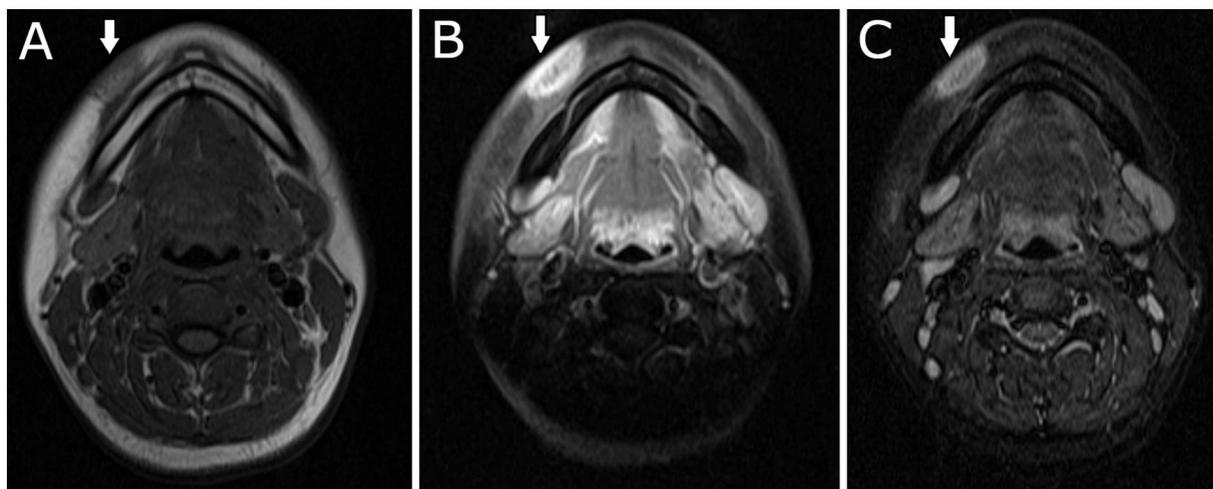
Axial MR images at the level of the mandible. Pre-contrast T1 (A), Post-contrast T1, fat-sat (B), and STIR (C) images demonstrate loss of the normal T1 bright fat signal, with heterogeneous geographical, reticular enhancement, without mass effect, involving the subcutaneous adipose layer along the right jaw.
